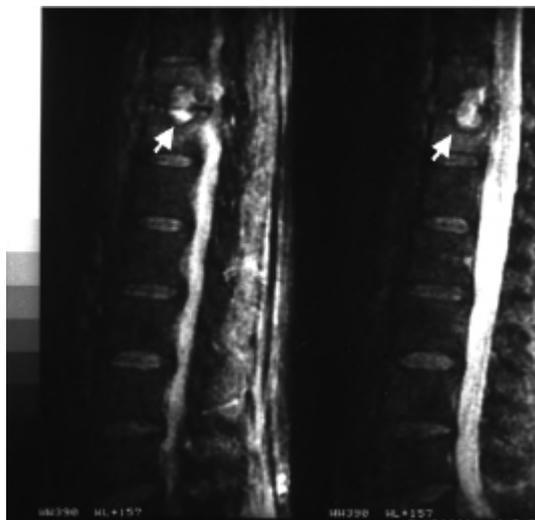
Nuclear magnetic resonance image of the spine showing a destructive lesion involving the T11-T12 discal space (arrow).
